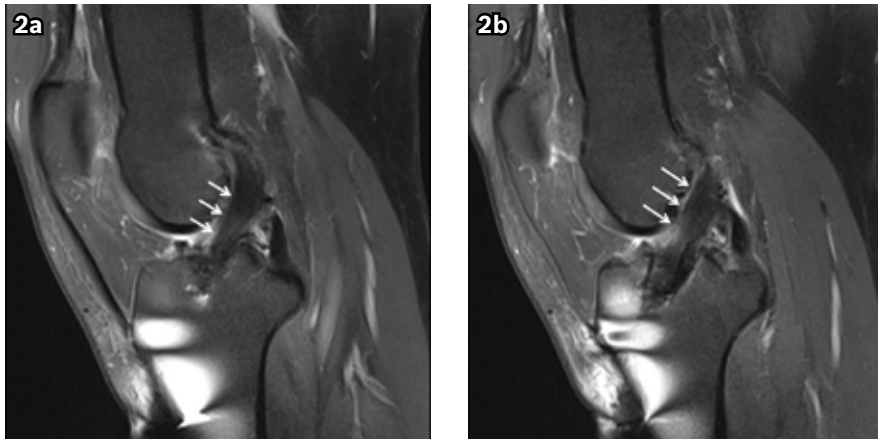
Post-ACL graft reconstruction images. (a & b) Contiguous sagittal PD-W MR images show the normal position of the ACL graft (arrows). The reconstructed anterior cruciate ligament graft is intact.
